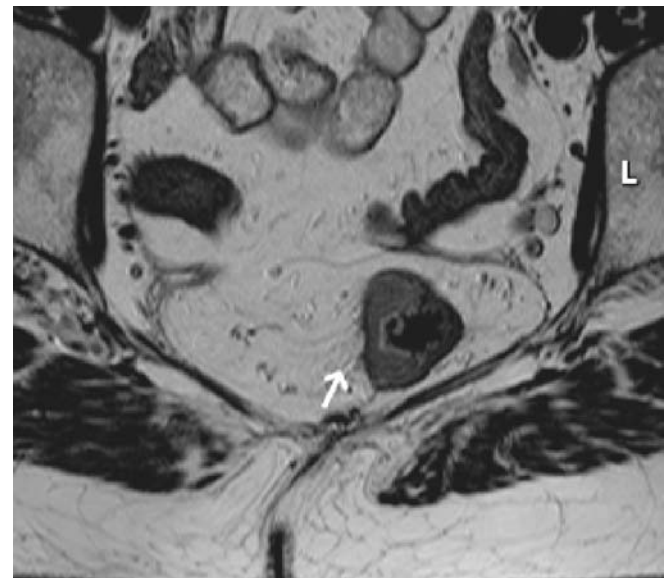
Paraxial T2-weighted FSE (TSE) sequence. Tumor of the rectal wall. Fibrous strands into the mesorectum represent desmoplastic reaction (arrow). A differentiation between desmoplastic reaction and tumor infiltration of the mesorectum can be difficult
